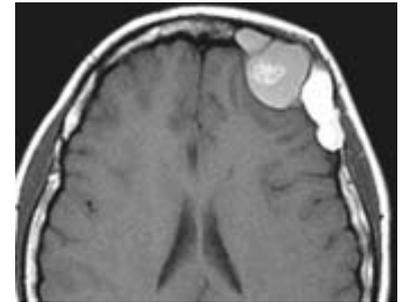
Axial magnetic resonance imaging demonstrating invasion intracranially as well as through the frontal bone into the subcutaneous tissue.
